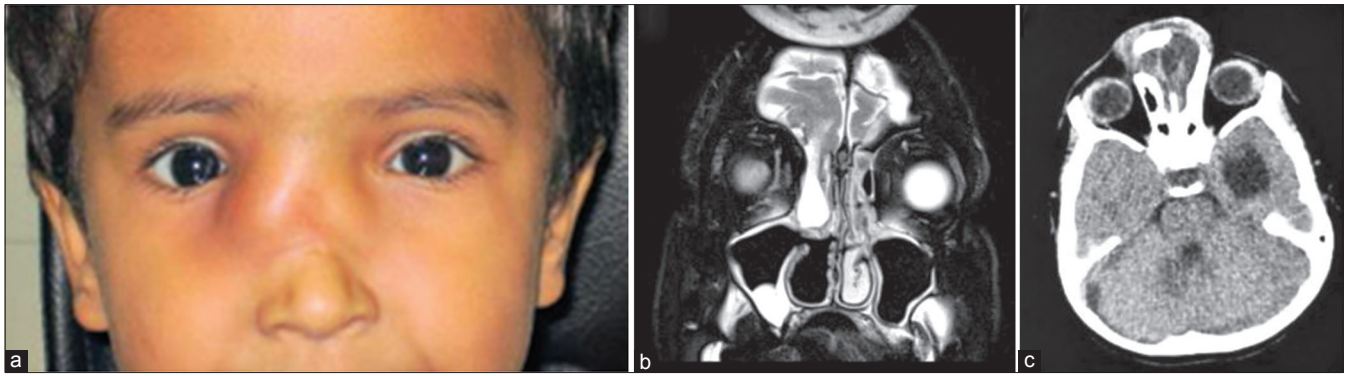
(a) A 6-year-old child presenting with a progressively enlarging swelling at the bridge of the nose which exhibited impulse on coughing and was accompanied by orbital hypertelorism. (b and c) Computed tomography scan revealed herniation and extrusion of cranial contents including meninges and brain tissue through a defect in the dura and anterior cranial base at the region of the foramen cecum, resulting in a frontoethmoidal encephalomeningocele
